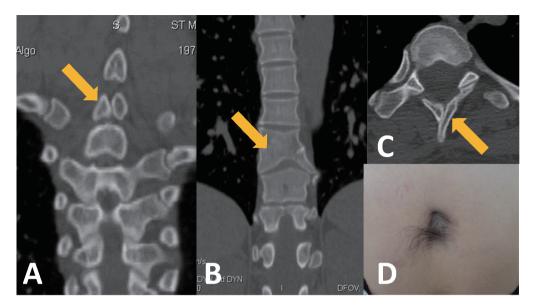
Cervicothoracic spine computed tomography (CT) shows bone anomalies in association with dermal sinus tract
